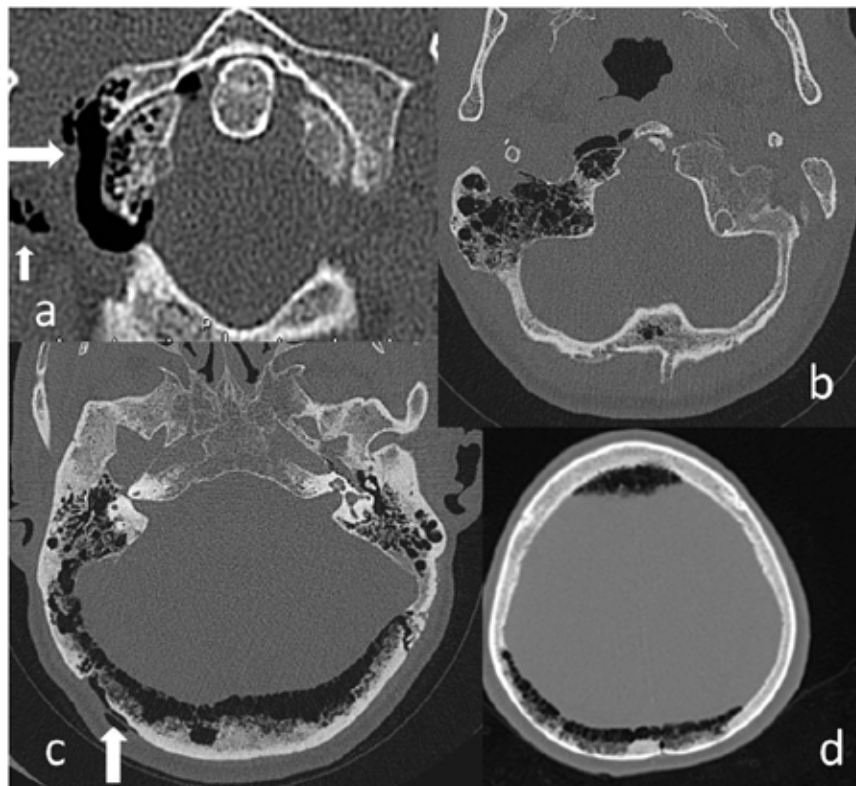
Axial cervical (a) and brain (b-d) sections of the CT. In (a), pneumatization of the right side of the atlas and free air around the right atlantooccipital joint (large white arrow) was seen. There was free air in soft tissue of the paravertebral region on same side also (small white arrow). Hyperpneumatization of the right mastoid bone, and right side of the foramen magnum (b), bilateral occipital bone (c), and bilateral parietal and frontal bones (d) was seen also. There was a small amount free air under the scalp of the right suboccipital region (white arrow in c).
